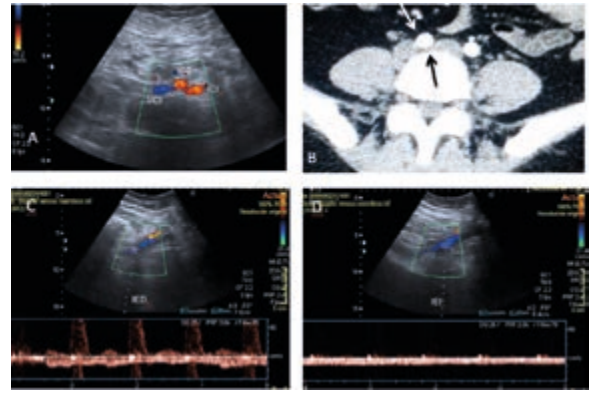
A) Cross-sectional view at umbilical level showing the right primitive iliac artery is observed (RPIA) and the absence of flow in the left primitive iliac vein, a direct sign of MTS. B) Correlation with the CAT scan: the RPIA compresses the left primitive iliac vein against the vertebral body (arrows). C) Comparative spectral Doppler between the right external iliac vein (preserved venous phasicity) and D) left external iliac veins with a flattened spectral pattern with loss of phasicity, an indirect sign of MTS.
